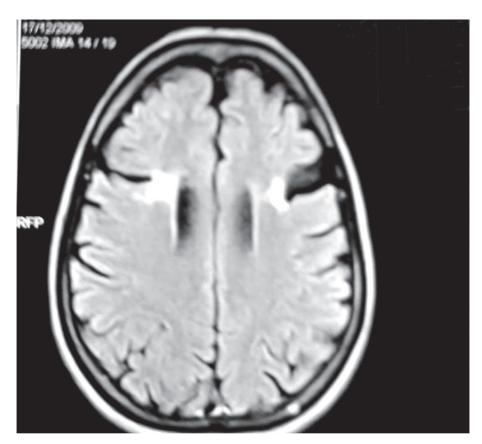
MRI Flair image of Patient 4 showing bilateral lesion in opercular region
